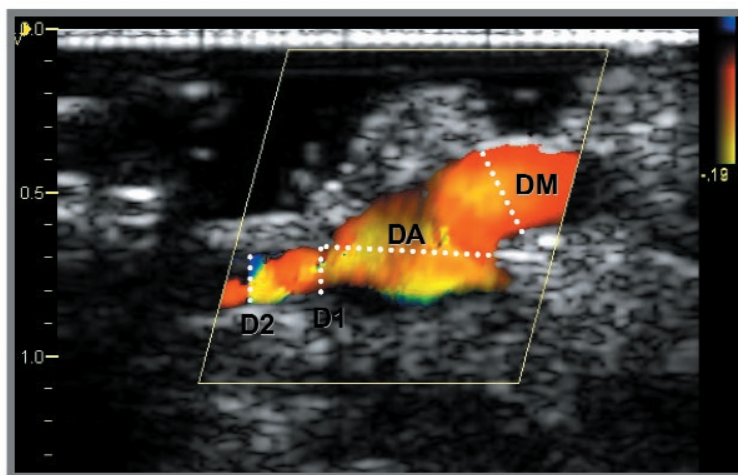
Parameters of the anastomosis of the left internal mammary artery (LIMA) to the left anterior descending coronary artery (LAD) viewed in the anterior-posterior plane and assessed by epicardial color Doppler ultrasound.  $D_A$  indicates the length of the anastomosis proper;  $D_M$ , the diameter of the LIMA;  $D_1$ , the LAD at the toe of the anastomosis;  $D_2$ , the LAD 5 to 10 mm distal to the anastomosis proper. The  $D_1/D_2$  ratio is 1.
